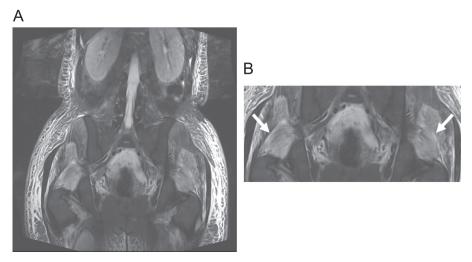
Coronal T2 weighted image of pelvic MRI. High signal intensity of bilateral piriformis muscle and gluteus minor muscle is noted (white arrows).
